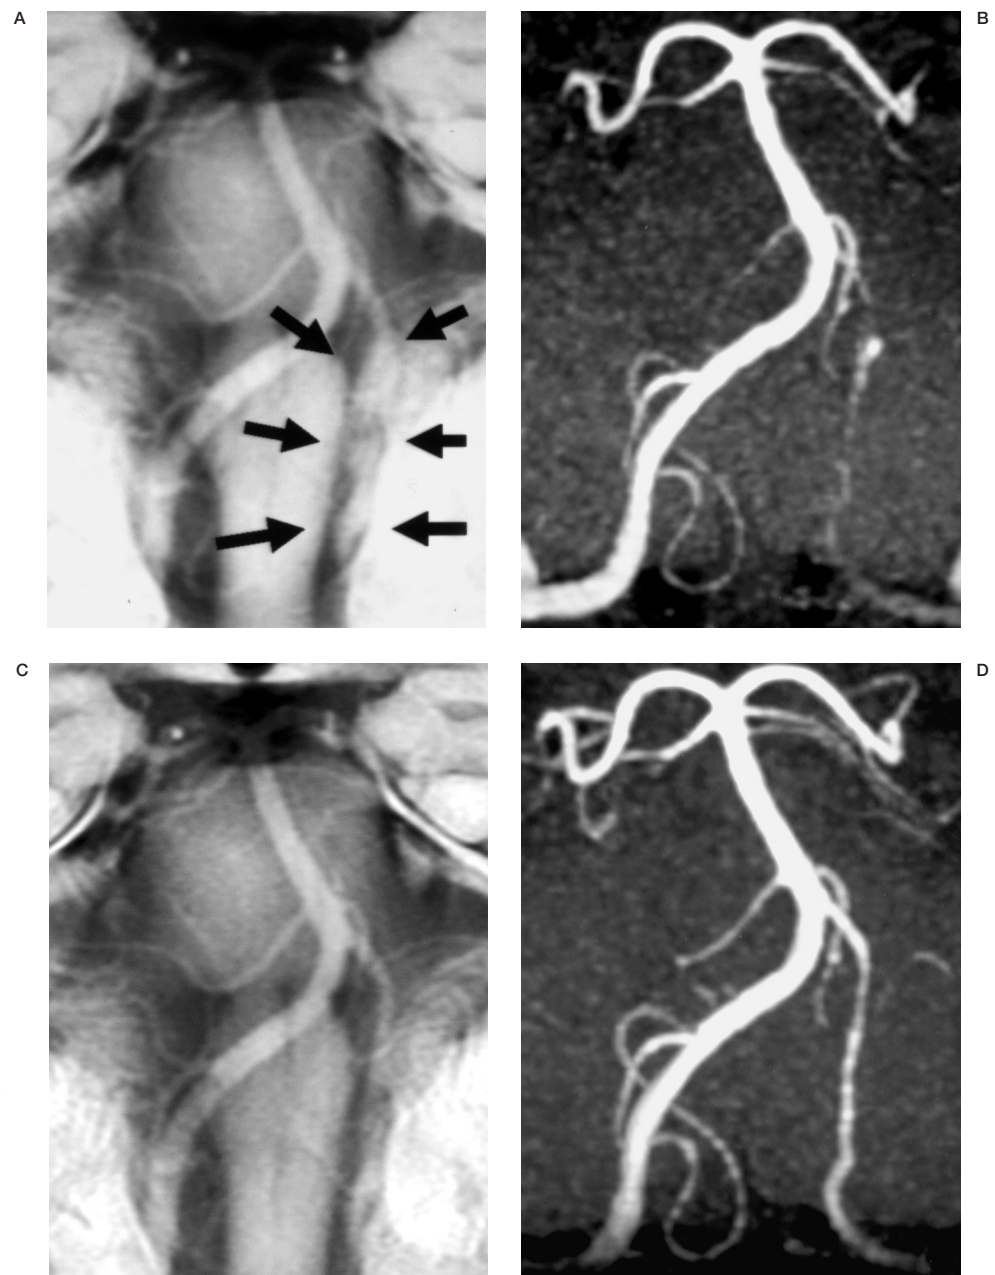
Case 2: 50-year-old male patient with left VA dissection. Initial BPAS-MRI (A) shows fusiform dilatation (arrows) of the left VA, though the MRA (B) indicates an irregularly narrowed left VA. Seven months after onset, BPAS-MRI (C) and MRA (D) show resolution of the fusiform appearance and the normalized inner caliber.
